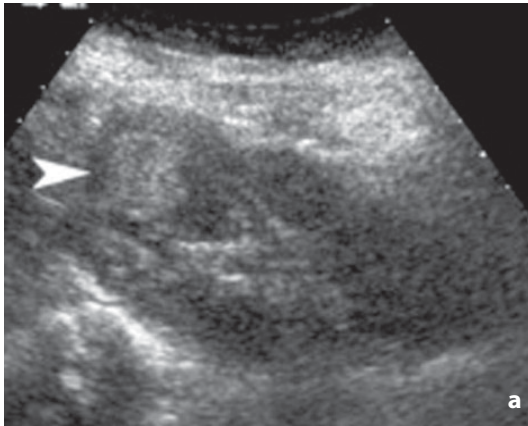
Ultrasonography. Renal cell carcinoma. a Sonogram shows a solid lesion with central hyperechoic components (*arrowhead*) in the upper third of the right kidney. b Solid hyperechoic lesion in the upper pole. c Solid mildly hyperechoic lesion (*arrows*) distorting the renal profile
